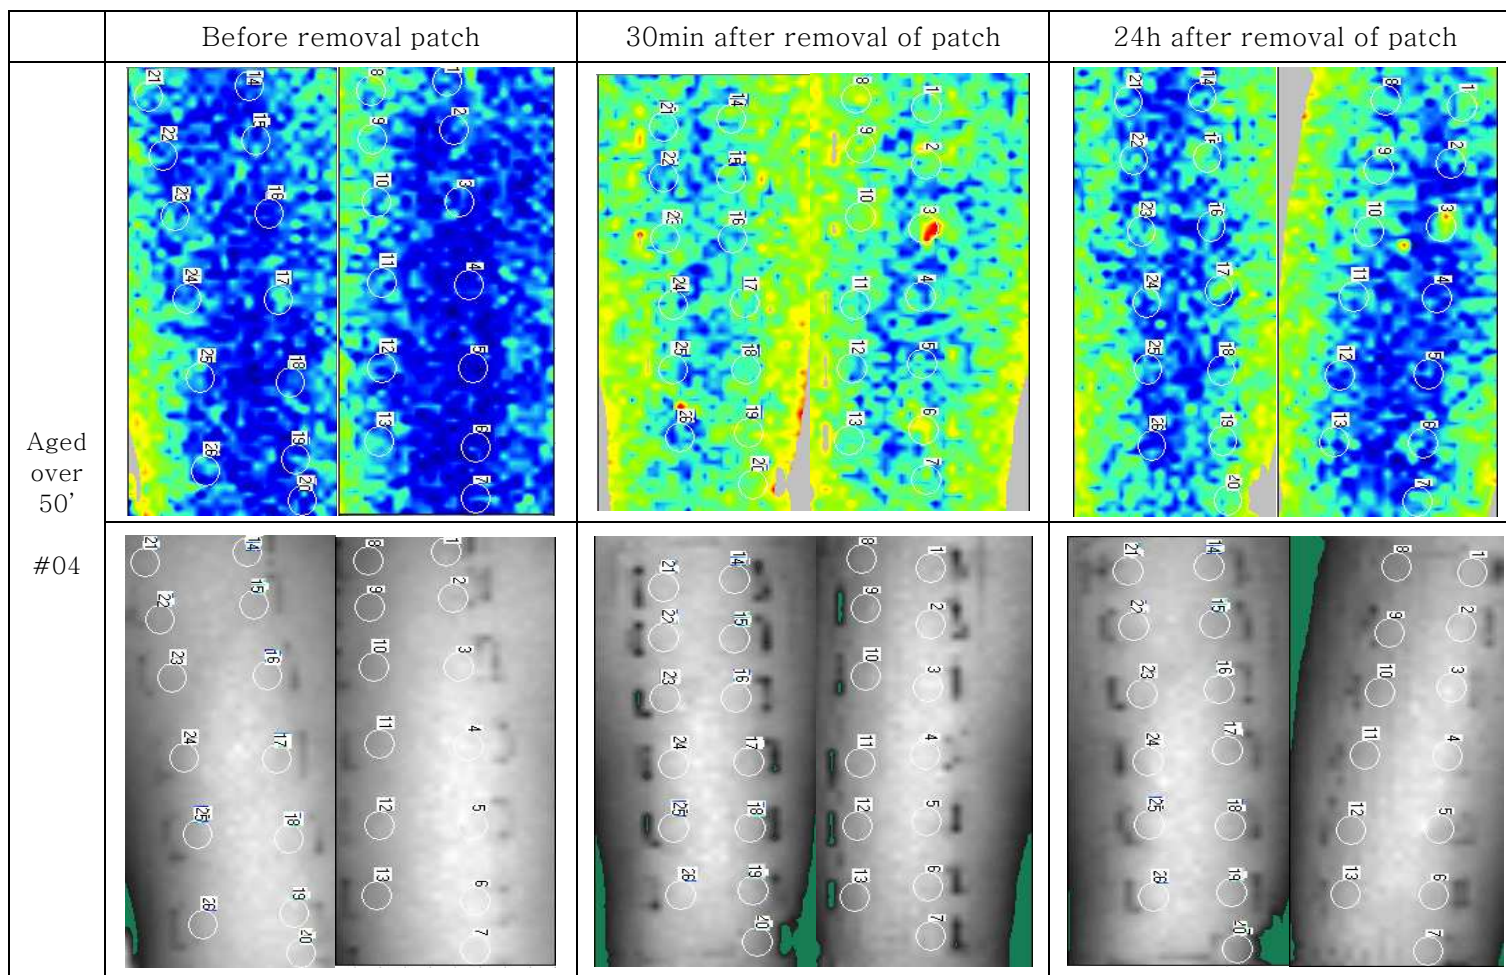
Image of perfusion by Laser Doppler Perfusion Image
